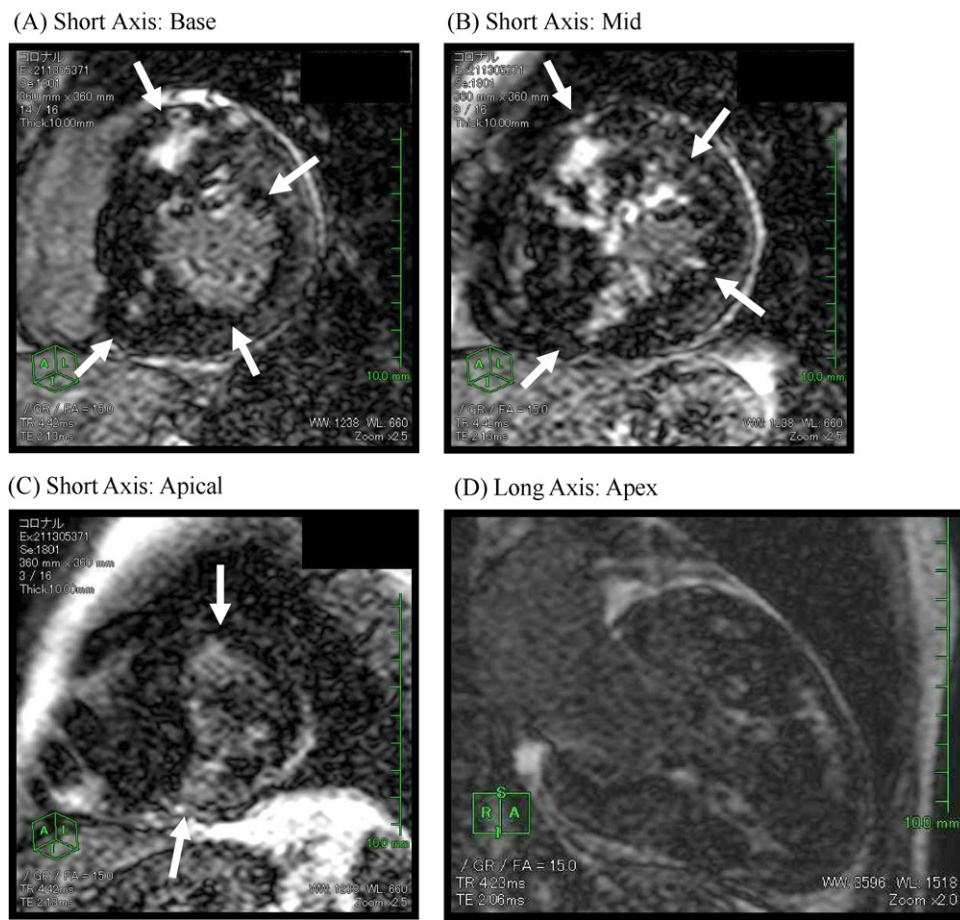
Representative findings of a patient with HCM with symptomatic VT/VF. A 35-year-old male patient was referred to our hospital because of sustained ventricular tachycardia. He was diagnosed with hypertrophic non-obstructive cardiomyopathy with echocardiography. Plasma BNP concentration was 711 pg/ml, and DGE score was 10. DGE images at (A) base, (B) mid, (C) apical levels in the short-axis view, and (D) apex in long-axis view are shown. Arrows indicate DGE positive segments that were found at base (segments 1, 3, 5, and 6), mid (segments 7, 9, 10 and 12), and apical levels (segments 13, and 15).
